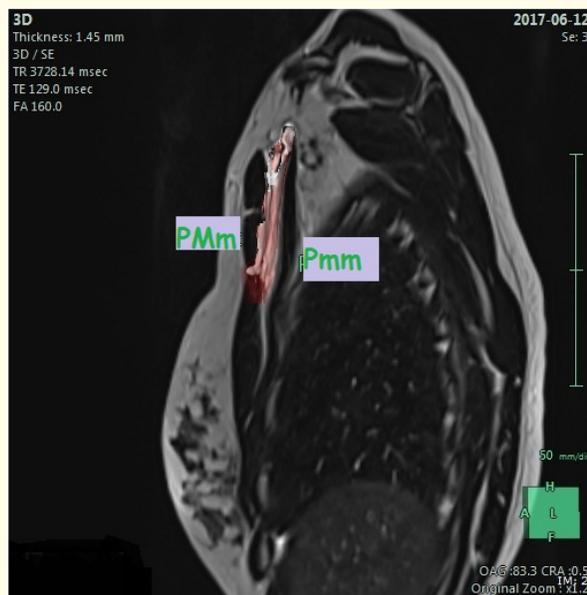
Typical 3D sagittal MRI of both axillary and interpectoral compartments. The fluid remained in the interpectoral compartment, with no spread into the axillary crease. PMm and Pmm represent the pectoralis major and pectoralis minor muscles, respectively.
